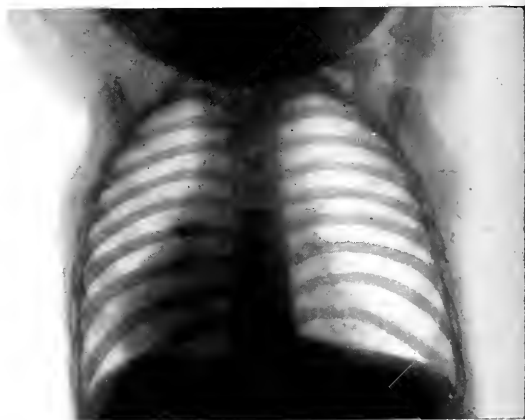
Pl. A., No. 198535; Serial No. 48535. Nov. 29, 1919. GRAPE STEM IN RIGHT BRONCHUS. Radiograph four days after accident. The characteristic roentgen signs of unilateral emphysema are clearly demonstrable. 1. Brilliant illumination of the right pulmonic field. 2. Flattening of the convexity of the diaphragmatic outline. 3. Displacement of median shadow to the left.
